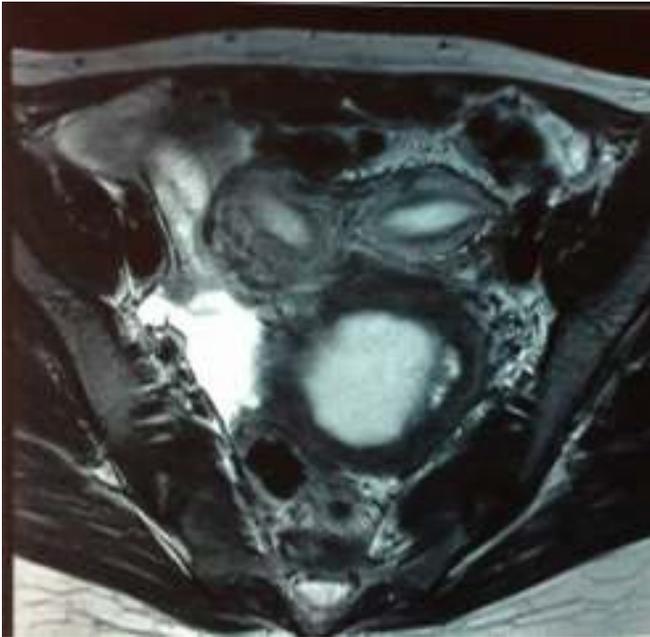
Magnetic Resonance Imaging showing didelphys uterus with hematocolpos
